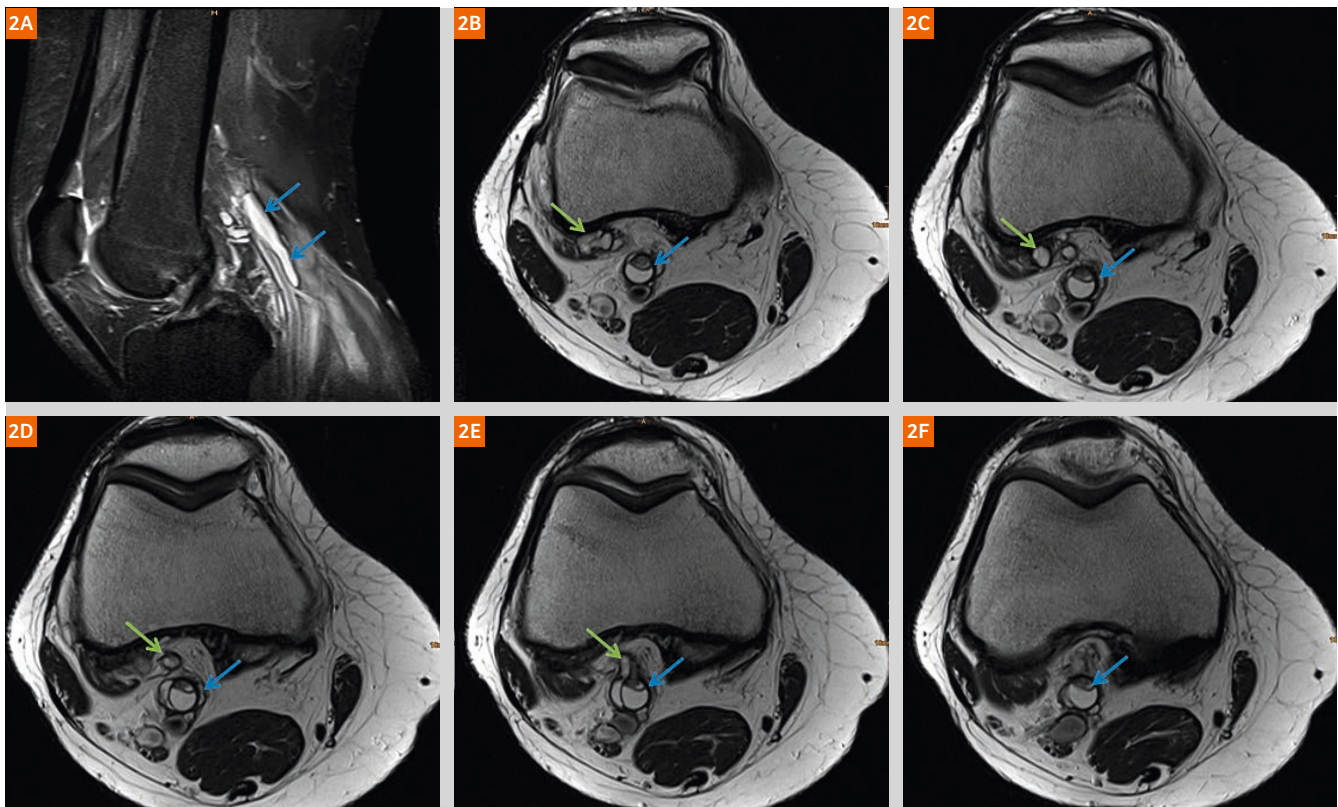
MRI of the knee (1.5T, MAGNETOM Avanto) demonstrating a cystic lesion that is adherent to the popliteal artery (blue arrow). Further we could demonstrate a connection to a ganglion that is adjacent to the knee joint (green arrow). Image 2A is a sagittal TIRM (TE 15 ms, TR 3160 ms, SL 3 mm, matrix 316 x 320) and images 2C–F are axial T2-weighted turbo-spin-echo sequences (TE 79 ms, TR 4680 ms, SL 3 mm, matrix 384 x 384).
